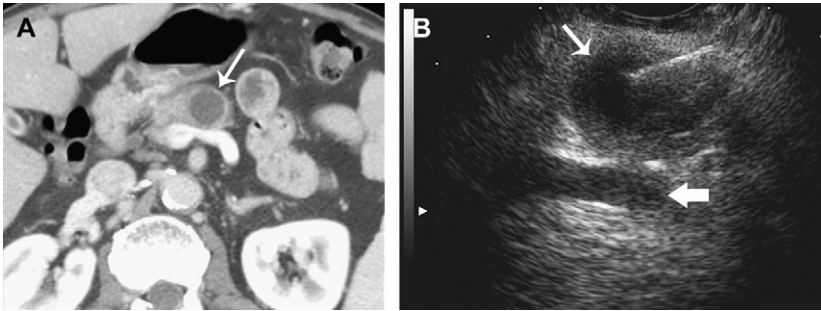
Sixty-one-year-old man who has a mucinous cystic neoplasm (cystoadenocarcinoma)—surgically proven. (A) Contrast-enhanced CT shows a cystic mass (arrow) in the neck of the pancreas, immediately adjacent to the splenic vein. The mass has a detectable wall but no obvious mural nodularity. (B) EUS shows a thick-walled cystic mass (arrow) just ventral to the splenic vein (block arrow). The FNA needle is seen and aspiration yielded thick mucinous fluid with an elevated CEA level.
